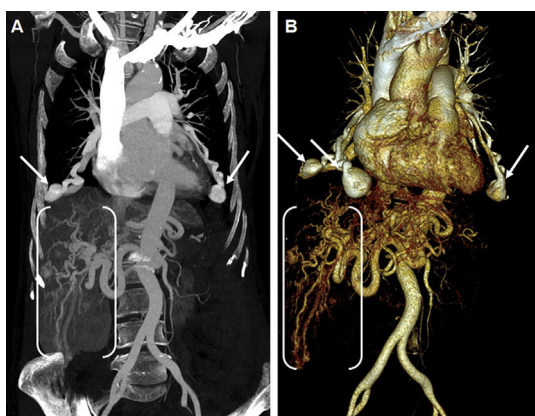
Coronal MIP image (A) and anterior view volume rendering 3D (B) thoracoabdominal CT angiographies showing multiple pulmonary (arrows) and hepatic arteriovenous malformations (between brackets).
